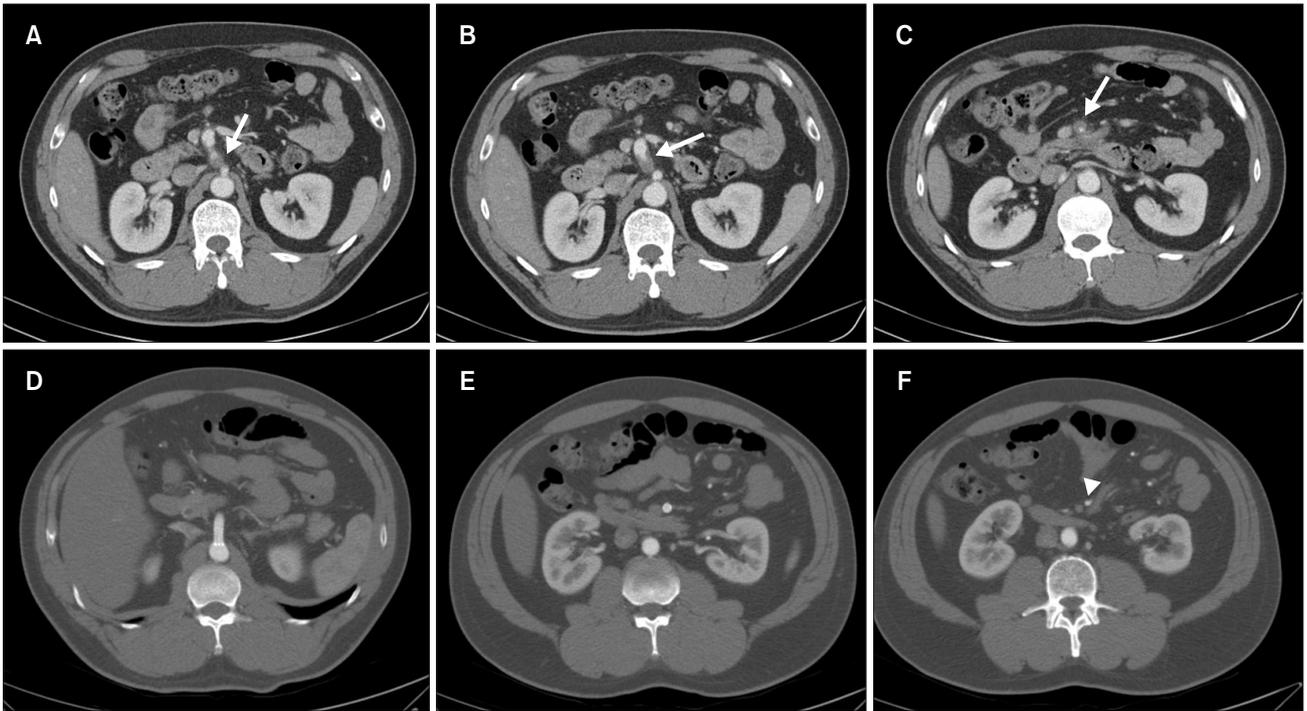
Representative computed tomography (CT) images of complete regression after endovascular intervention for spontaneous isolated dissection of the superior mesenteric artery. CT images before intervention (A-C) and 12 months after intervention (D-F). White arrows, dissection; arrowhead, complete regression.
